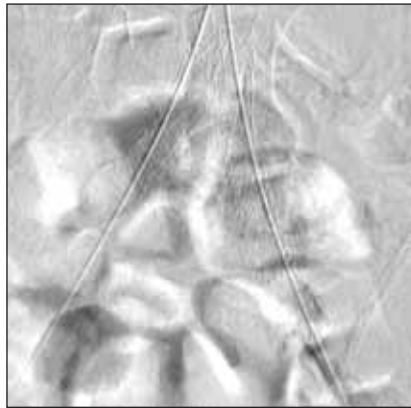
Plain film during angiographic imaging showing the previously placed kissing iliac stents.
